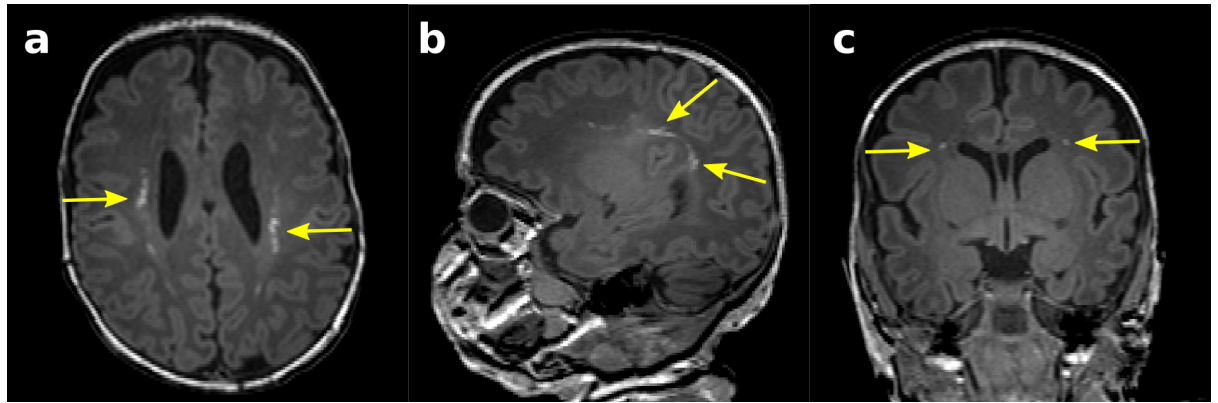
Punctate lesion in an infant born at 28.9 weeks GA and imaged at 41. 6 weeks PMA, shown on T1-weighted image in the axial (a), sagittal (b) coronal view (c).
